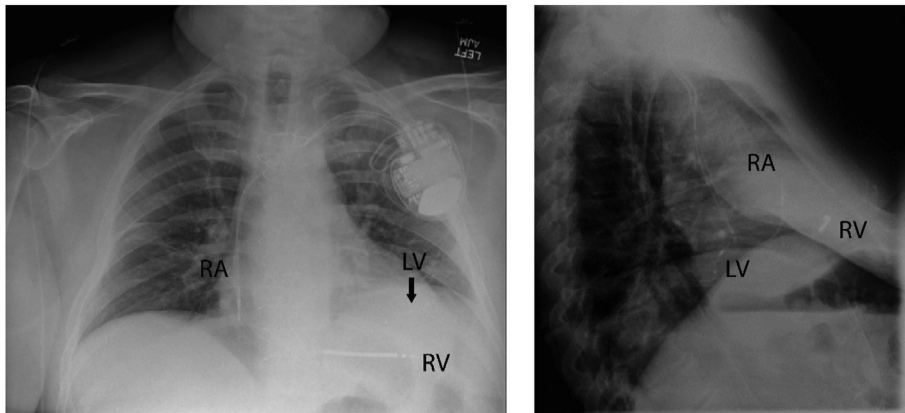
Postimplant chest radiograph. There is mild vascular congestion present. LV = left ventricular lead; RA = right atrial lead; RV = right ventricular lead.
